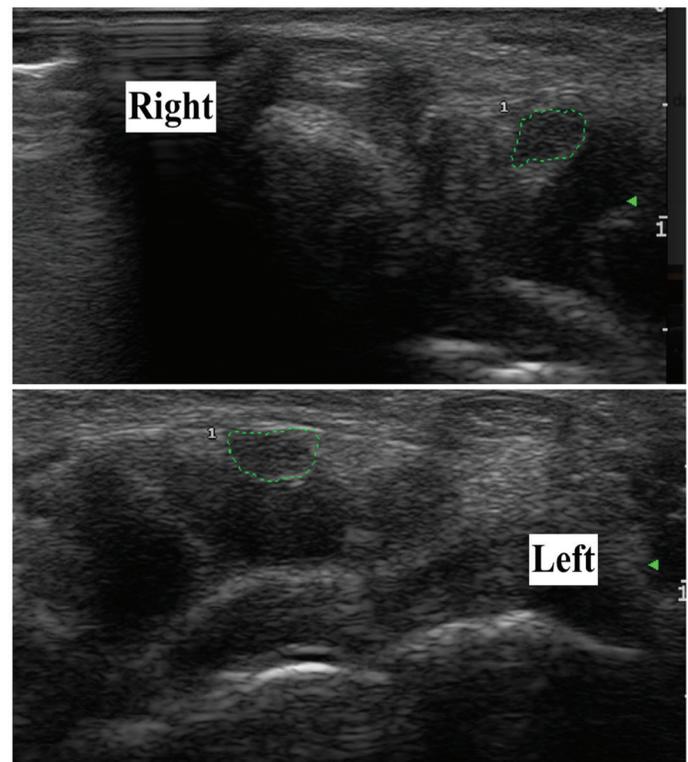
It shows a cross-section area of the right and left median nerve with wrist level gray scale ultrasound (dot lines indicate median nerve)
